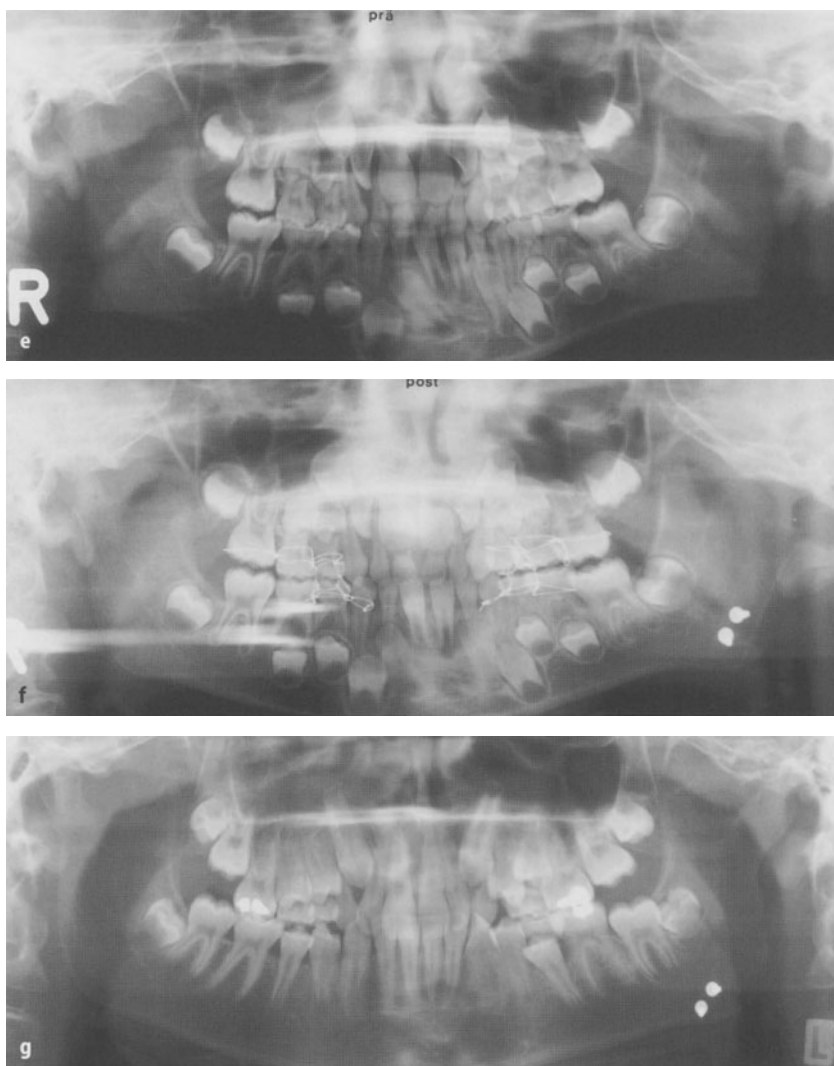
Unilateral congenital aplasia of the condyle. a–d Patient's appearance at the age of 7 years with chin deviation, reduced facial height on the affected left side, severe deviation of the mandible at maximum mouth opening, but little lack of downward growth of the maxilla. e Panoramic radiograph discloses a normal mandible on the right side. The left side is lacking in height in the body and the ascending ramus. There is an almost rectangular gonion angle with a flat depression in front of it, but there is no condyle present. The neck of the condylar process is like a broad stump, covered by a sclerotic surface. f, g Panoramic radiograph after reconstruction of the missing condyle by a costo-chondral graft, soon after operation and 6 years later
